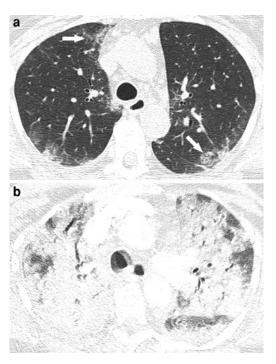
Acute exacerbation of NSIP. a HRCT image shows multiple foci of peripheral ground-glass opacity (*arrows*). b HRCT image one month later shows extensive consolidation in both lungs. The patient presented with acute hypoxia and dyspnea
